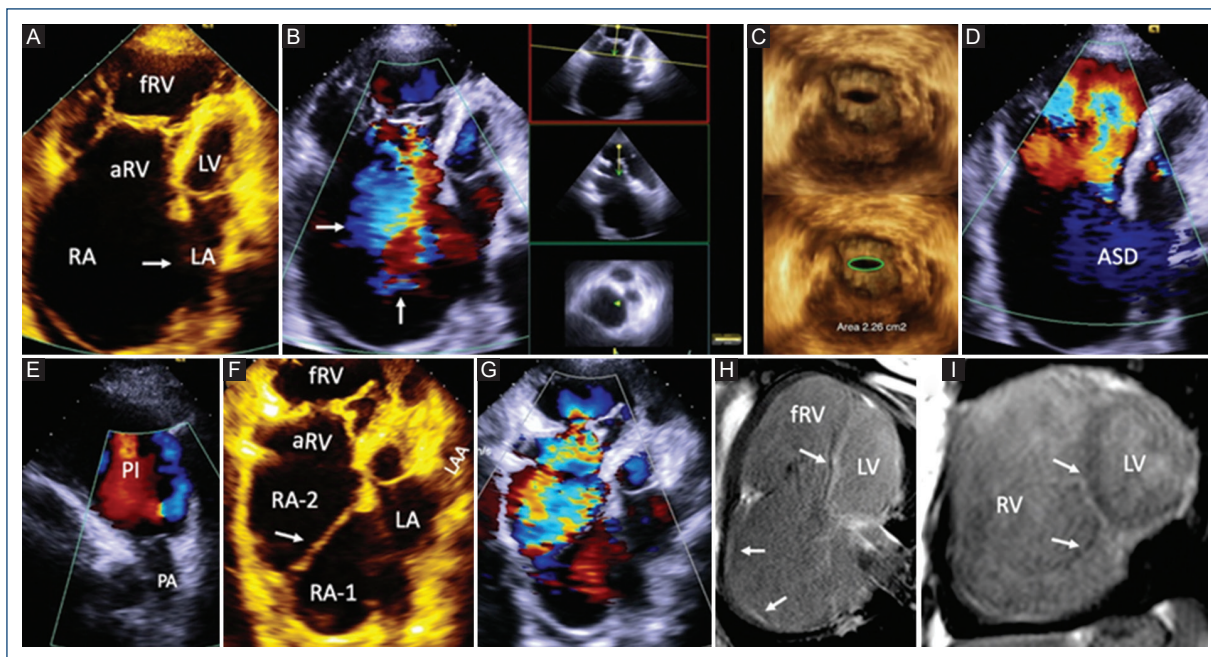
Transthoracic 2-D and 3-D echocardiography and cardiac magnetic resonance. A: Four-chamber view showing moderate Ebstein's anomaly with atrial septal defect (arrow). B: Severe tricuspid regurgitation (arrows). C: 3D echocardiogram showing tricuspid stenosis area of 2.26 cm². D: Atrial septal defect with right to left shunt. E: Infundibular dilation and normal pulmonary valve. F: Modified four chamber view showing the membrane (arrow) dividing the right atrium in two chambers: RA1 and RA2. G: Color Doppler revealed severe tricuspid regurgitation and non-obstructive membrane. H: Four-chamber view and I: short axis of both ventricles with the right atrial and septal fibrosis, also fibrosis in the sites of septal and posterior leaflets adherence to the right ventricle, (arrows). RA: right atrium; aRV: atrialized right ventricle; fRV: functional right ventricle; LA: left atrium; LV: left ventricle; ASD: atrial septal defect; PI: pulmonary infundibulum; PA: pulmonary artery; RA-1: right atrium 1; RA-2: right atrium 2; LAA: left atrial appendage.
